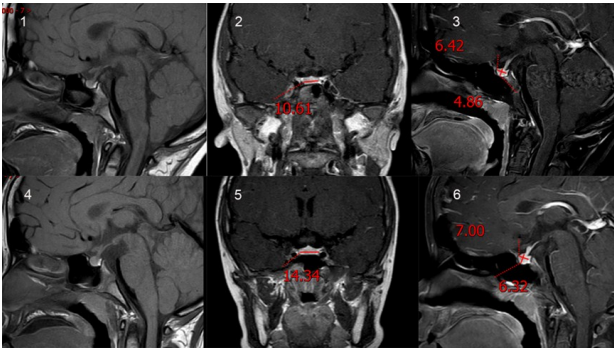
Typical MRI images. (1-3) Before the patient's treatment, 1: MRI scanning T1WI sagittal position showing pituitary morphology, 2: T1+C delayed phase coronal position showing uniform pituitary enhancement, with left and right meridian size of 10.61mm, 3: T1+C delayed phase sagittal position showing uniform pituitary enhancement, with anterior and posterior radial sizes of 6.42mm and upper and lower high meridian sizes of 4.86mm. (4-6) After treatment of the patient, 4: MRI scanning T1WI sagittal position showing pituitary morphology, 5: T1+C delayed phase coronal position showing uniform pituitary enhancement with left and right meridian sizes of 14.34mm, 6: T1+C delayed phase sagittal position showing uniform pituitary enhancement with anterior and posterior radial sizes of 7.00mm and upper and lower high meridian sizes of 6.32mm.
